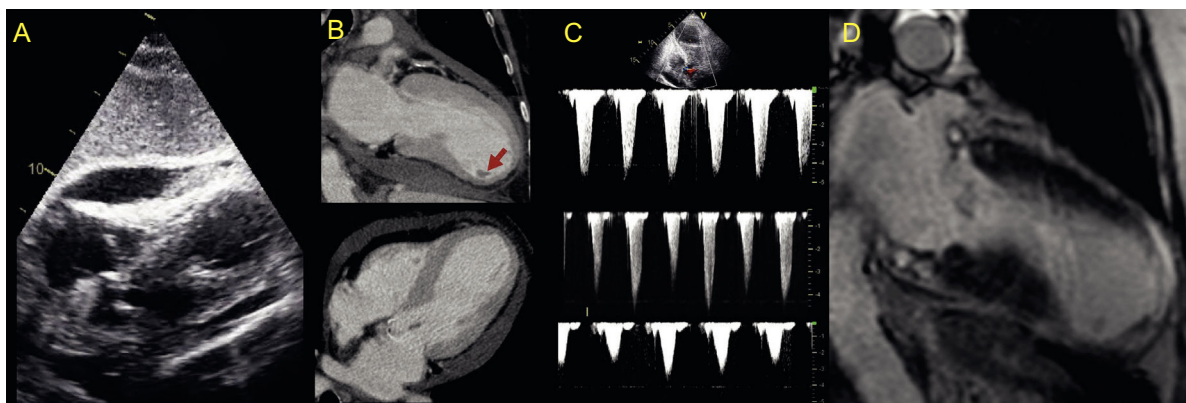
A. Pericardial effusion on transthoracic echocardiography. B. Cardiac computed tomography depicts a thrombus adhering to the inferoapical segment (arrow). C. Continuous Doppler signal in the left ventricular outflow tract. D. Cardiac magnetic resonance.
